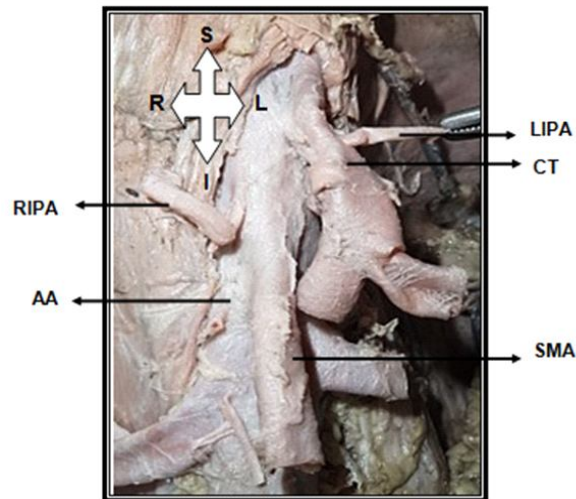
Origin of LIPA and RIPA from CT individually
